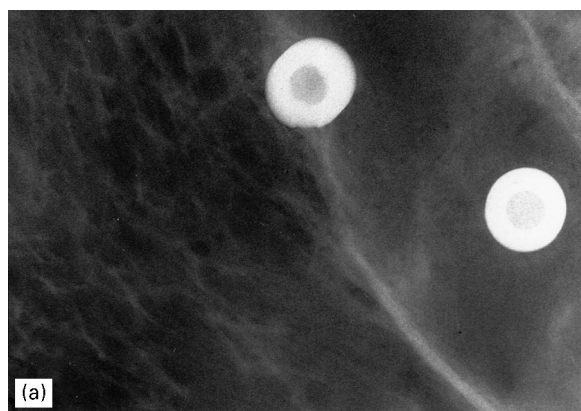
(a) Radiograph of two implants located in the canal mandibularis, taken perpendicular to the long axis of the implant. (b) Radiograph of two implants surrounded by trabecular bone, in the vicinity of the canal mandibularis.
